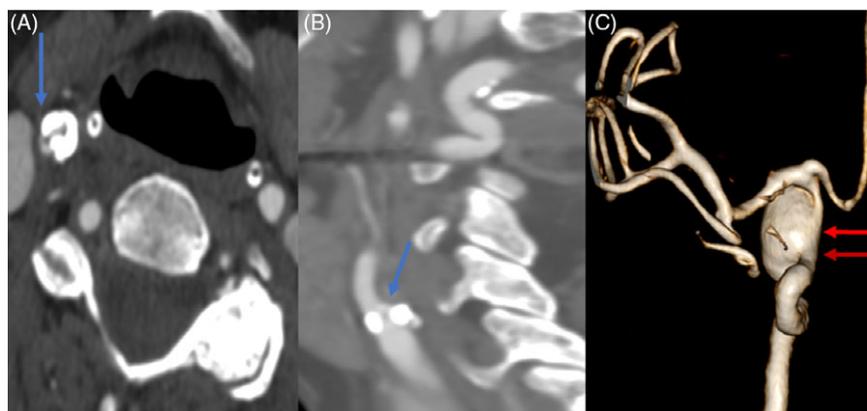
Neck CT angiography in axial (A) and sagittal reformat (B) demonstrating severe stenosis of the right ICA by calcified atherosclerotic plaque (blue arrow A and B). Cerebral angiogram 3D reformat (C) demonstrating right ICA – supraclinoid aneurysm with wide neck (arrow).
